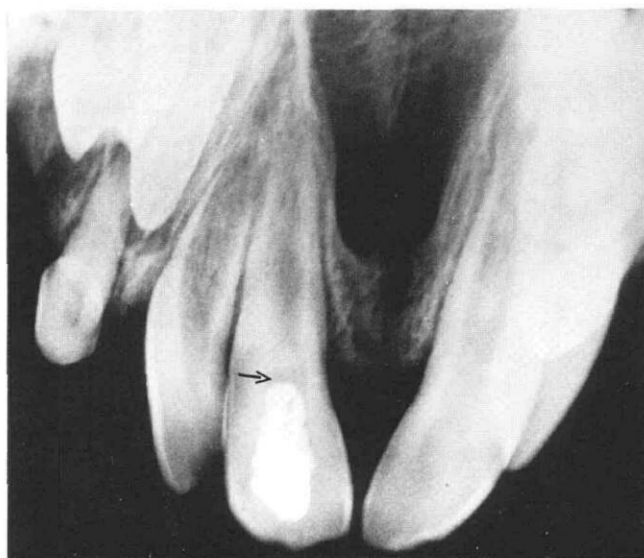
Periapical radiograph of pulpotomized permanent maxillary central incisor showing a normally developed root, an almost closed apex and a dentin bridge. Note the radiolucent area between the bridge and the formocresol dressing.
